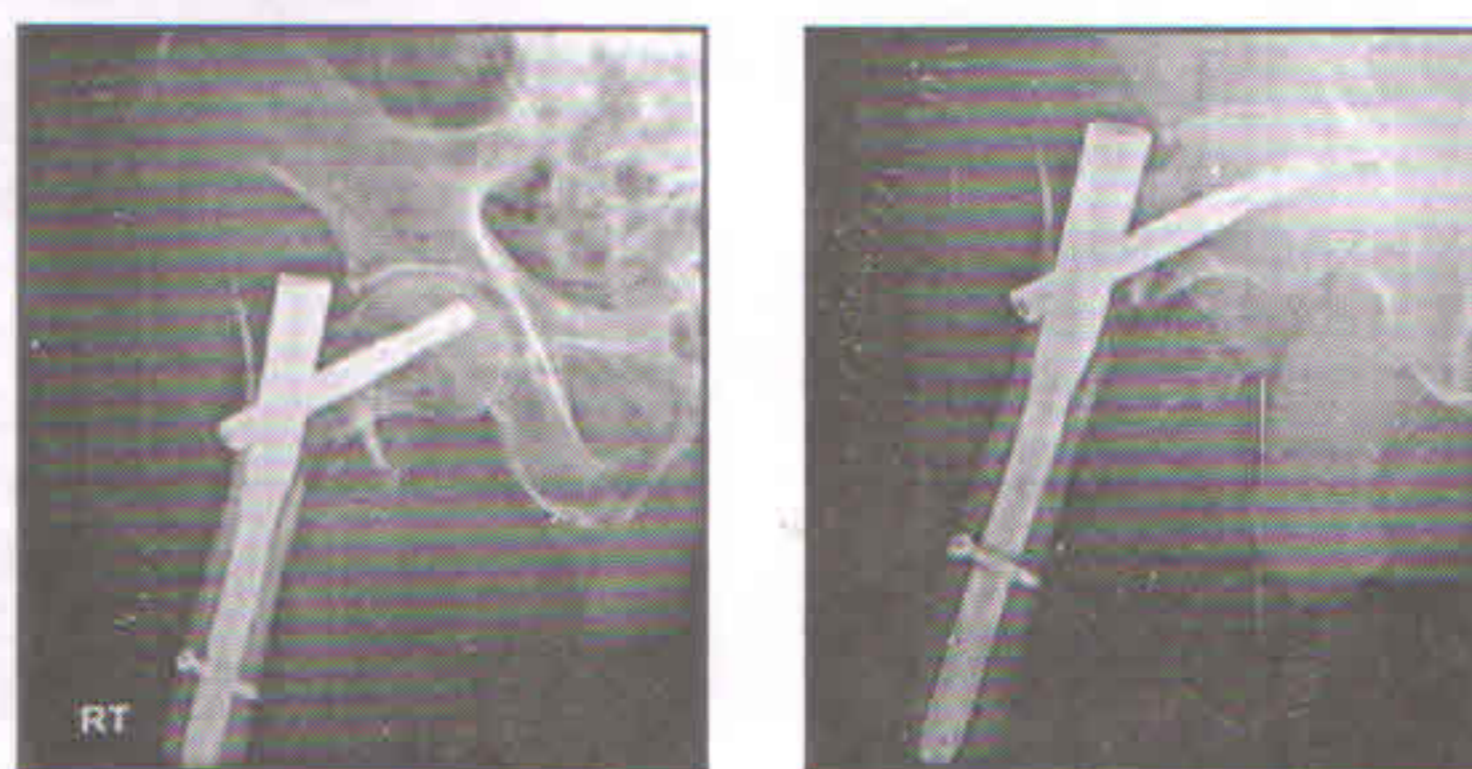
Post operative Radiographs showing excellent reduction and ideal placement of the PFNA.
